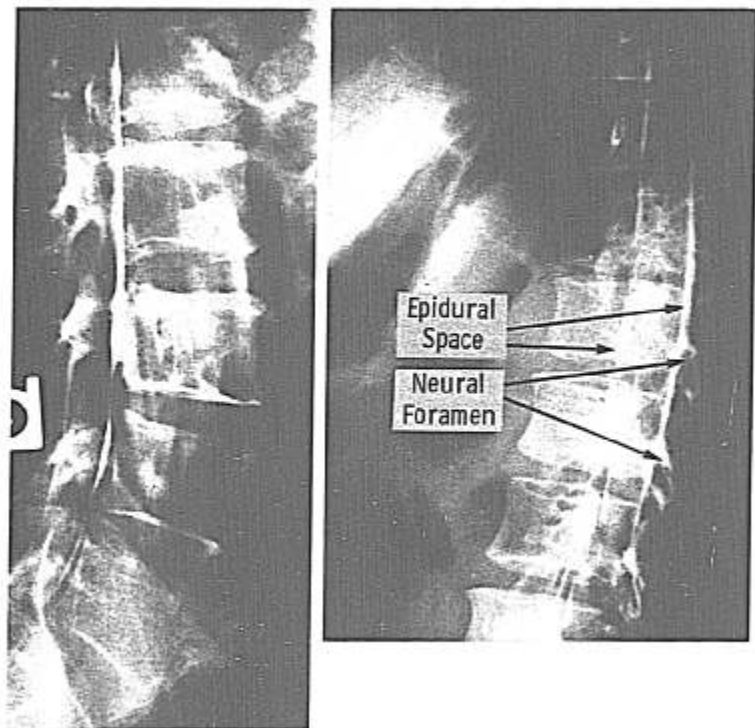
(left). Radiograph of lumbar vertebral area of an elderly arteriosclerotic patient, taken after epidural injection of local anesthetic along with radiopaque material. Note that the only spread of this material is longitudinal, without any paravertebral spread due to closure of the intervertebral foramina.
